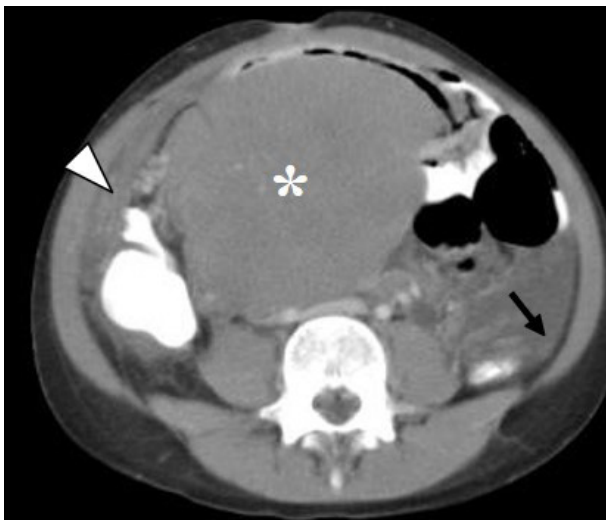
Repeat CT scan approximately at the same level as in Fig. 2. The node has evolved into a huge mass at the inferior mesentery (*). Note omental thickening on the right (arrowhead) and an enhancing nodular peritoneal reflection (black arrow).
